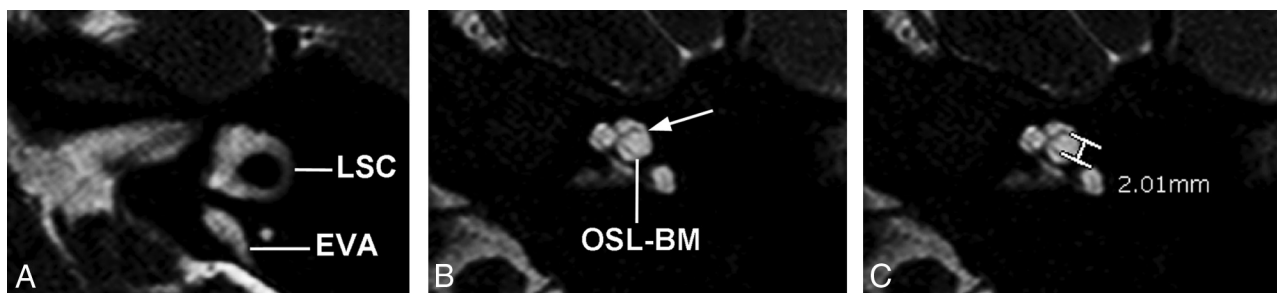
Axial 3D cisternographic (DRIVE) fast-recovery TSE MR image of the right temporal bone in a patient with a prospectively diagnosed IP-II anomaly. *A*, Reformatted images parallel to the lateral semicircular canal (LSC) are created. Once created, the lateral semicircular canal is seen in its entirety on a single reformatted image. Note the enlarged vestibular aqueduct. *B*, The osseous spiral lamina–basilar membrane complex of the upper basal turn (OSL-BM) and the first T2-hypointense linear band (*arrow*), in this case representing a band of dysplastic osseous spiral lamina–basilar membrane neural complex, are demonstrated. *C*, A caliper is then placed to measure the distance between the OSL-BM and the linear band (distance X).
